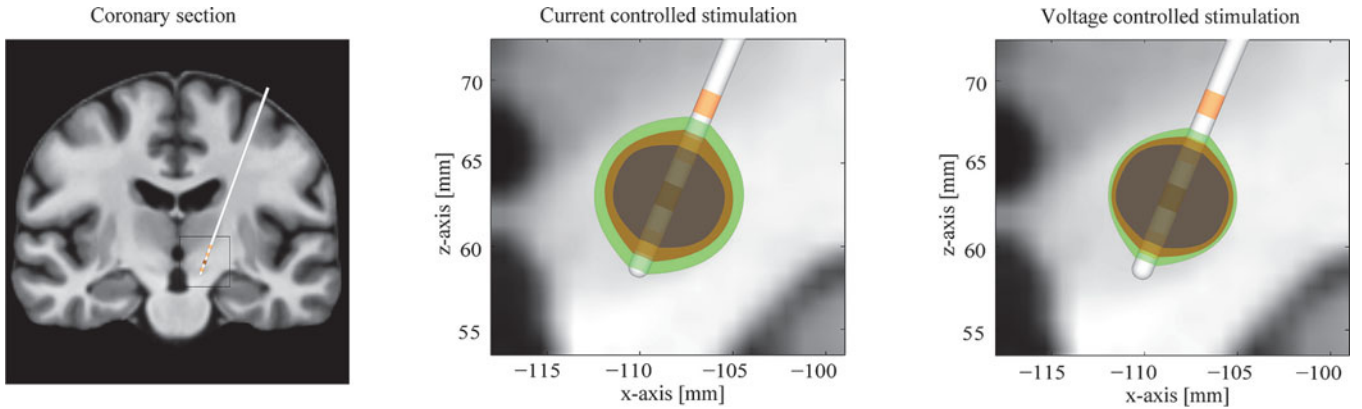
Coronary section of the MRI dataset with the DBS electrode and the ROI overlaid with the probabilistic VTA for current-controlled stimulation ( $-1.5$  mA) and voltage-controlled stimulation ( $-1.5$  V). The mean VTA (orange), 0.025 quantile (dark blue), and 0.975 quantile (green) for random conductivity with a relative standard deviation of 20% are shown.
